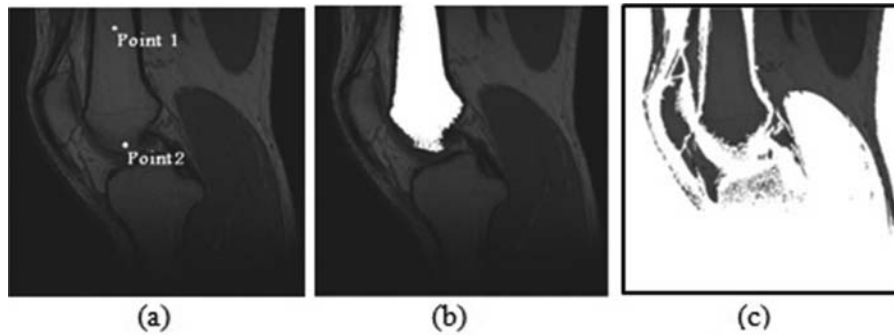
Performing region growing on an MRI bone image. (a) Original images with two seed points. (b) Region growing result for seed point 1. (c) Region growing result for seed point 2.
